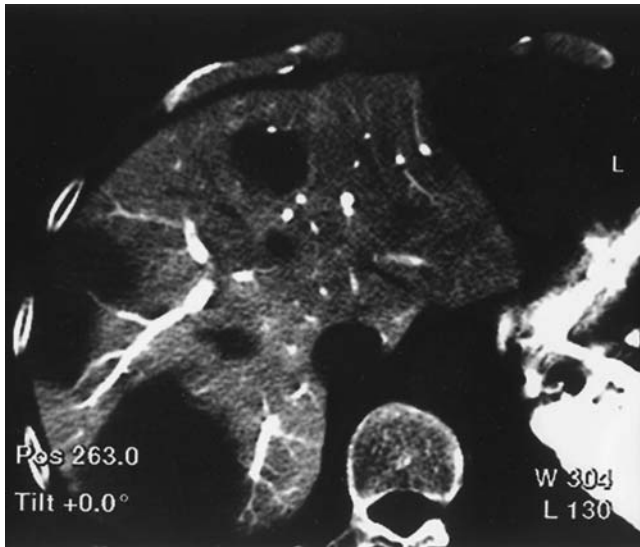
A preprocedural computed tomography during arterial portography slice shows multiple metastases in segments 4, 6, and 7
